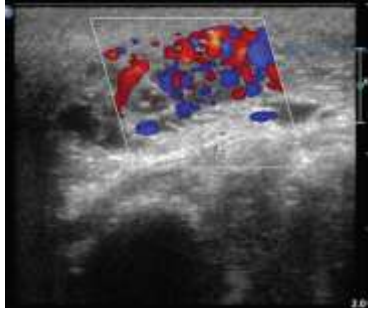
Color Doppler USG showing intense vascularity and presence of both arterial and venous flow⁽²⁴⁾
